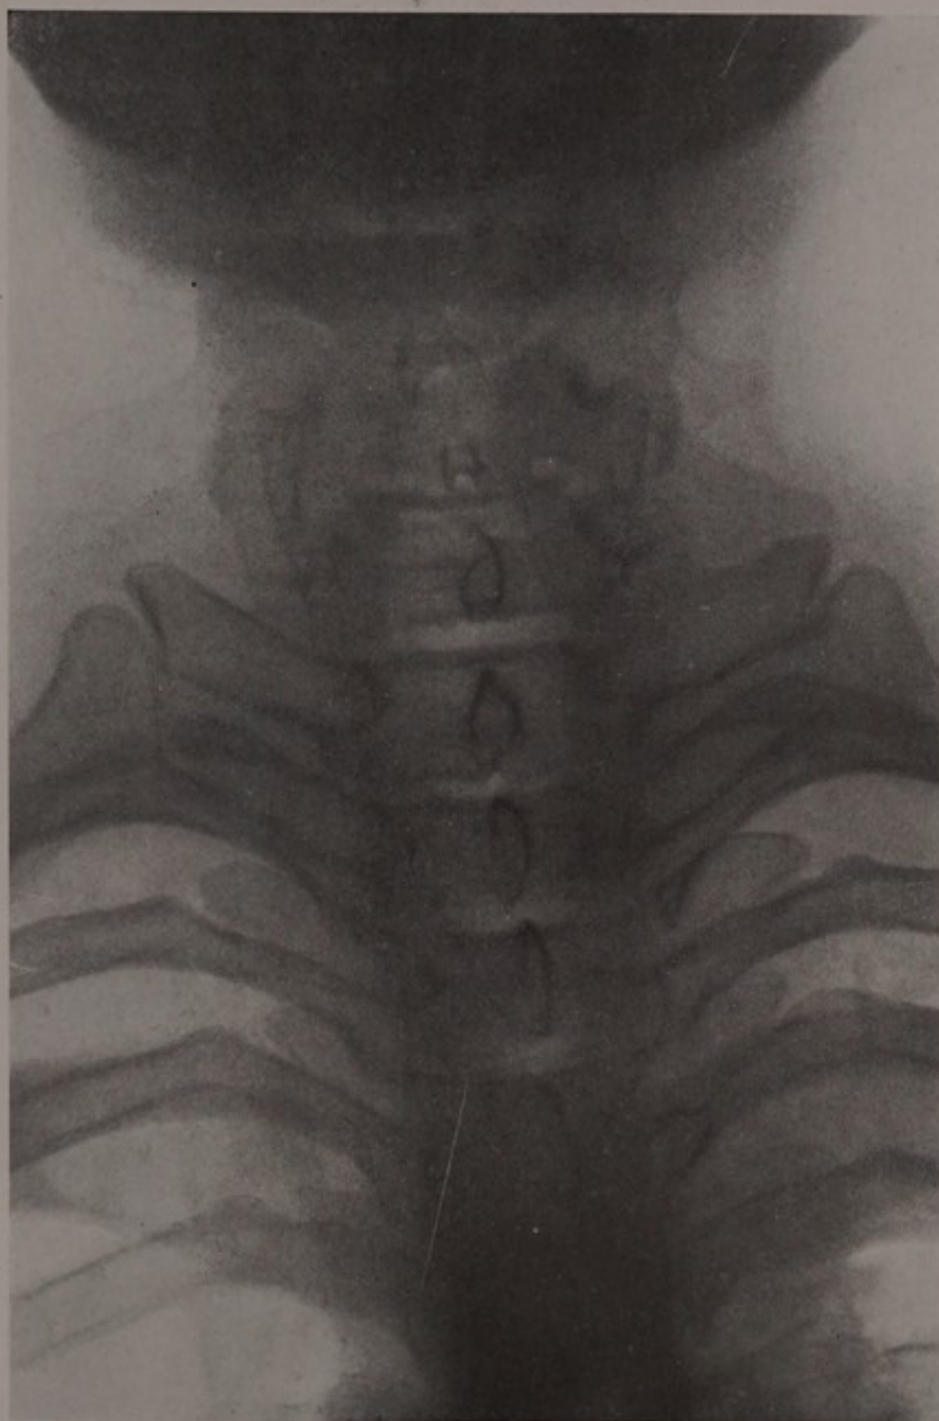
X-ray of crushing fracture of the third, fourth, fifth and sixth cervical vertebrae.
